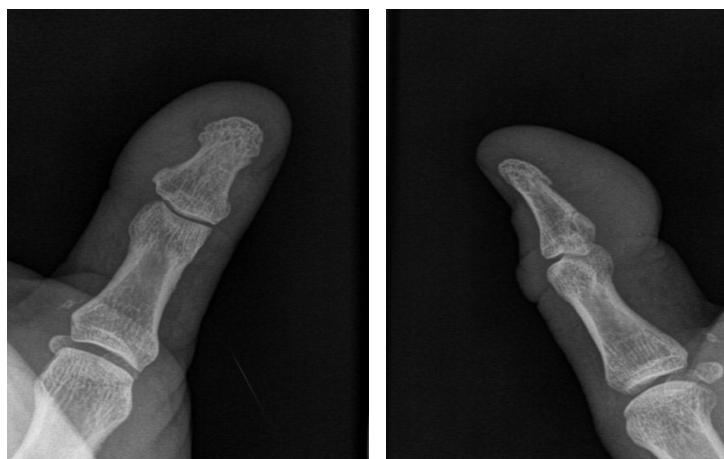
Native radiographs of the right thumb
